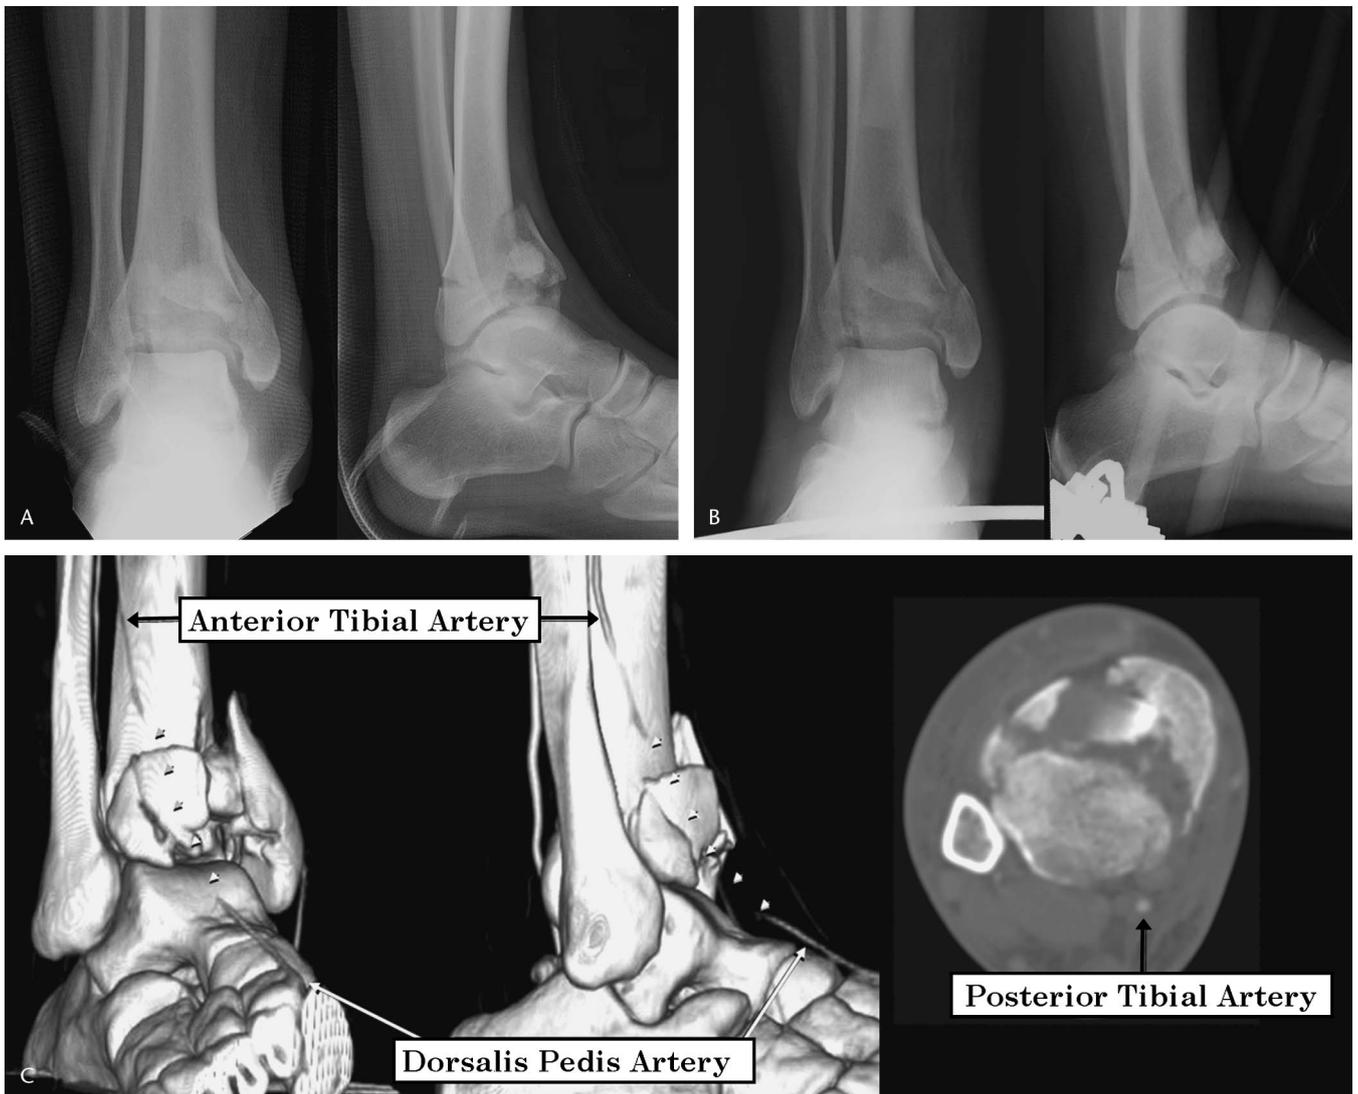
Case example. A, Injury radiographs demonstrating C3 fracture in a 24 year old man injured in a motorcross crash; B, Radiographs after application of external fixator and fixation of fibula; C, Shaded surface reconstruction of CT demonstrating perfusion deficit (arrowheads) of anterior tibial artery. Apparent collateral flow is seen in the dorsalis pedis artery via the posterior tibial artery. Corresponding axial CT demonstrating fracture pattern and arterial contrast evident only in the posterior tibial artery.
